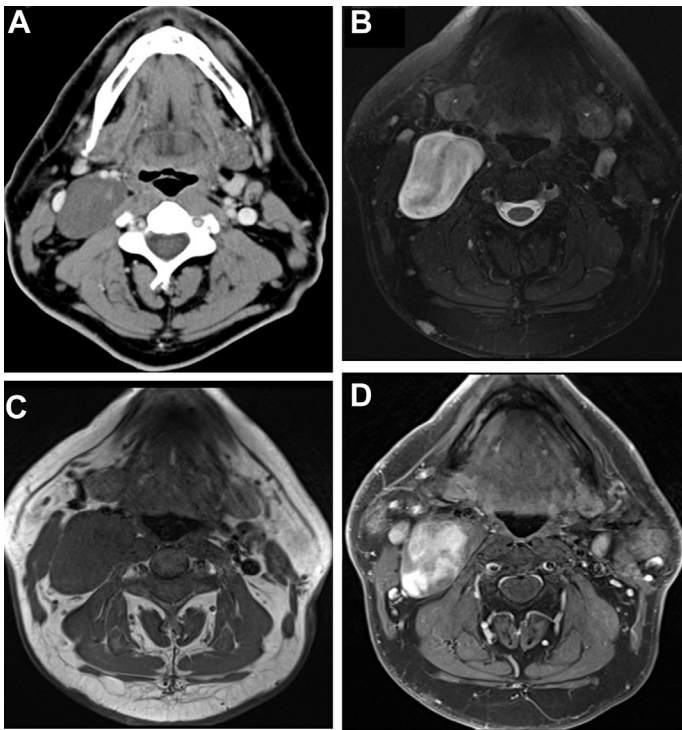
Sympathetic trunk neurofibroma in a 47-year-old male patient with NF1. (A) Contrast-enhanced CT shows a well-defined low-density mass in the right carotid space with minimal enhancement. (B, C) On axial fat-suppressed T2WI and T1WI, the mass is hyperintense and isointense compared with muscle. (D) Contrast-enhanced fat-suppressed axial T1WI shows heterogeneous enhancement in the mass.
